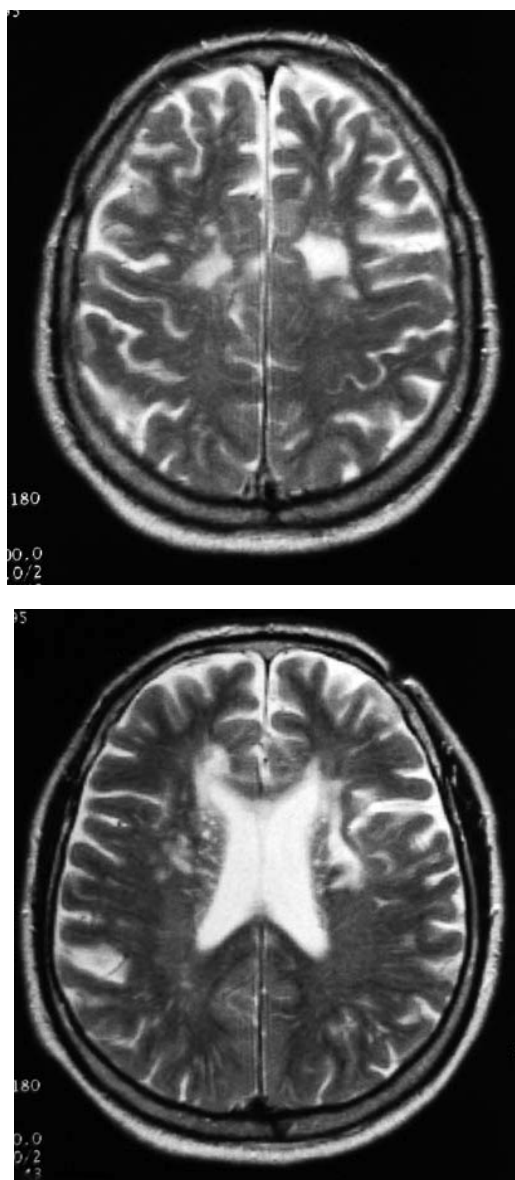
Axial sections of the brain MRI of a 58-year-old supervisor in the cleaning and degreasing industry reveal small and large focal lesion in deep white matter and large frontal capping and irregular lining in periventricular white matter in  $T_2$ -weighted images. The patient had been exposed mainly to trichloroethylene for 43 years (OELY 8), he had no other diseases, he did not smoke, and his average alcohol consumption was 39 g/month.
